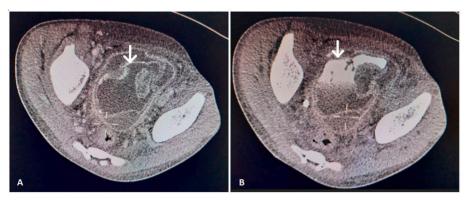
CT scan showing a bladder rupture in the anterior wall of the bladder (arrow).
